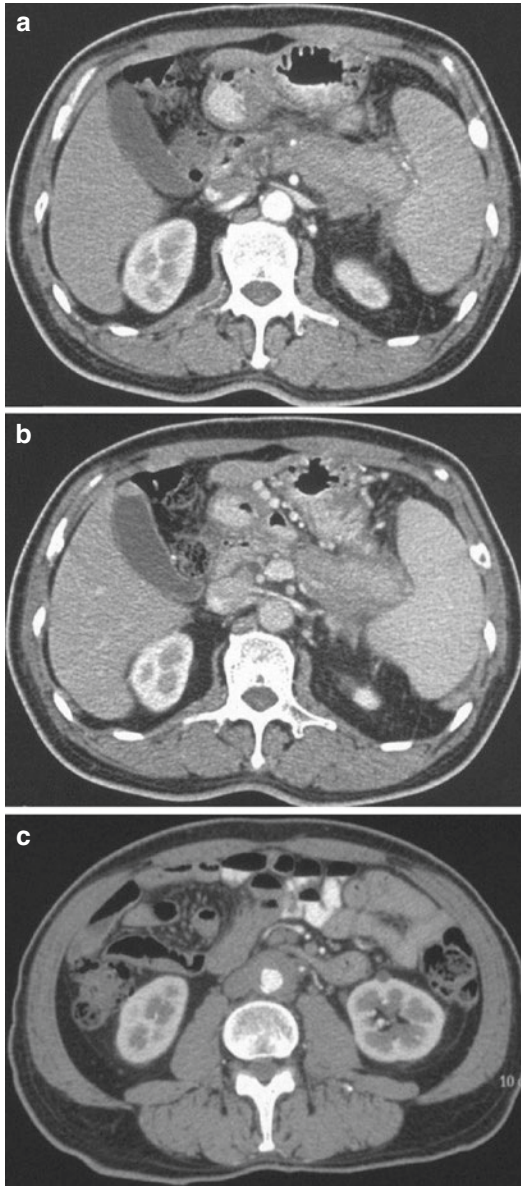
(a) CT revealed enlargement of the pancreatic body and tail with poorly defined margins, peripancreatic fluid collections, and thickening of peripancreatic fatty tissue. (b) CT revealed gastric varices. (c) CT revealed abdominal aorta compressed below the opening of renal artery
